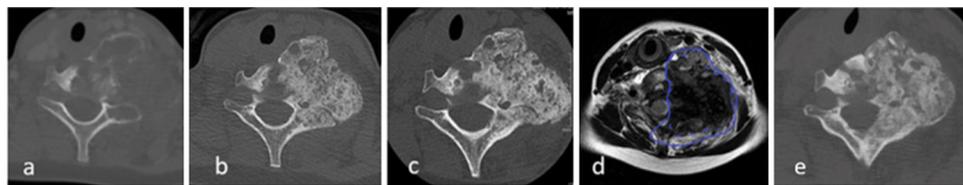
Patient #3 a, b, c, and d: Computed tomography and magnetic resonance imaging, axial views; (a) at diagnosis; (b) 6 months after denosumab initiation; (c) 12 months after denosumab initiation; and (d) 4 months after denosumab discontinuation, with a dotted line to indicate the cyst contours; 10 months after denosumab discontinuation, the solid line delineating the cyst contours indicates an increase in size; e: Computed tomography, axial view 12 months after the resumption of denosumab therapy.
